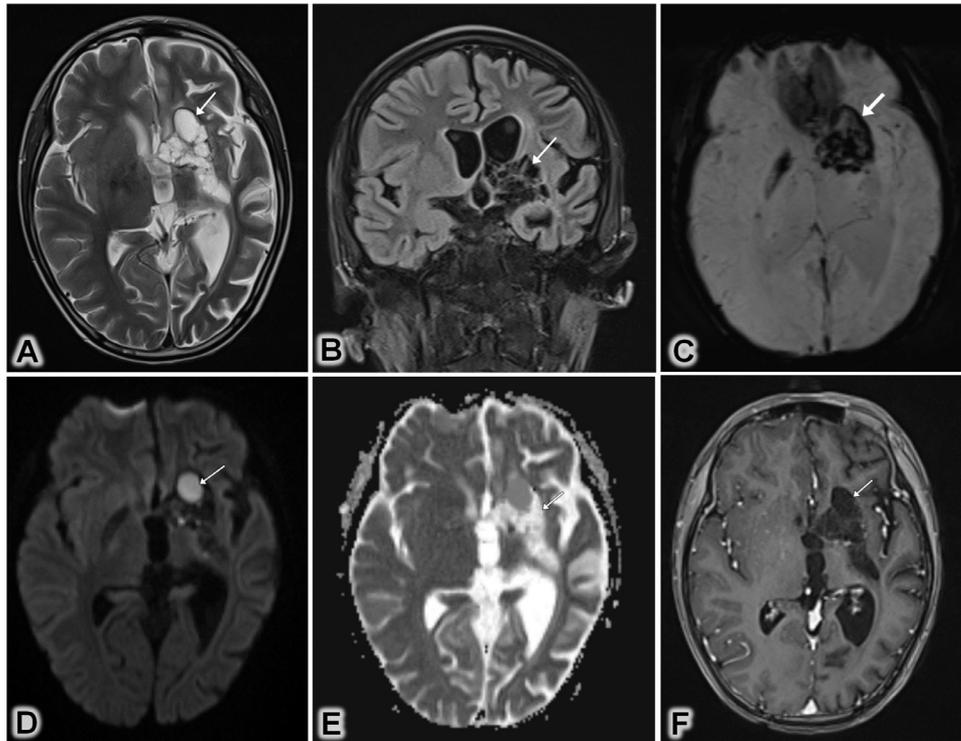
Case 2: Post-treatment MRI image, including (A) axial T2W, (B) coronal FLAIR, (C) axial SWI, (D) axial DWI, (E) axial ADC, (F) axial T1W post-contrast, demonstrated a cystic lesion in the lentiform nucleus, head of the caudate nucleus, and the left temporal lobe uncus, with evidence of bleeding, and no postcontrast enhancement (white arrowhead).
